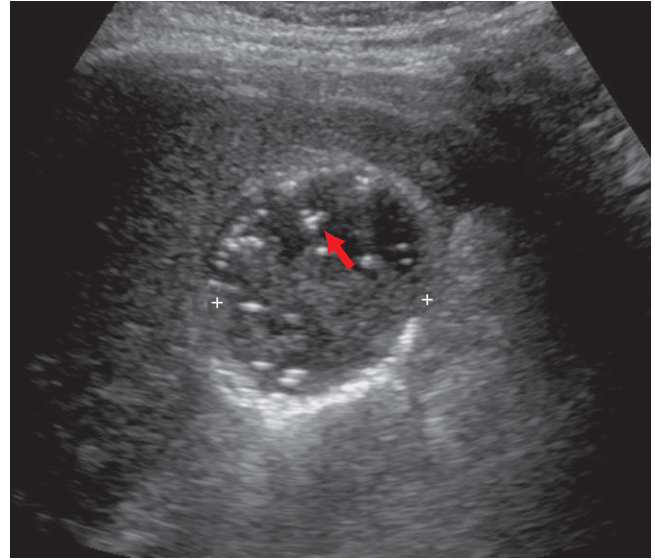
The transverse sonographic image of the gallbladder shows air within the wall and multiple echogenic foci (arrow) consistent with air within the lumen.
